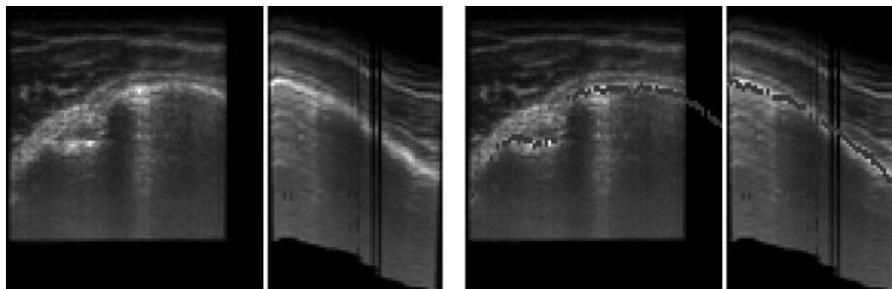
Registration of an in vivo dataset of a human humerus. Shown are an axial and a sagittal slice through the three-dimensional ultrasound dataset in the area of the sulcus intertubercularis. The gray lines in the images on the right indicate the position of the bone surface extracted from the CT-dataset after registration.
